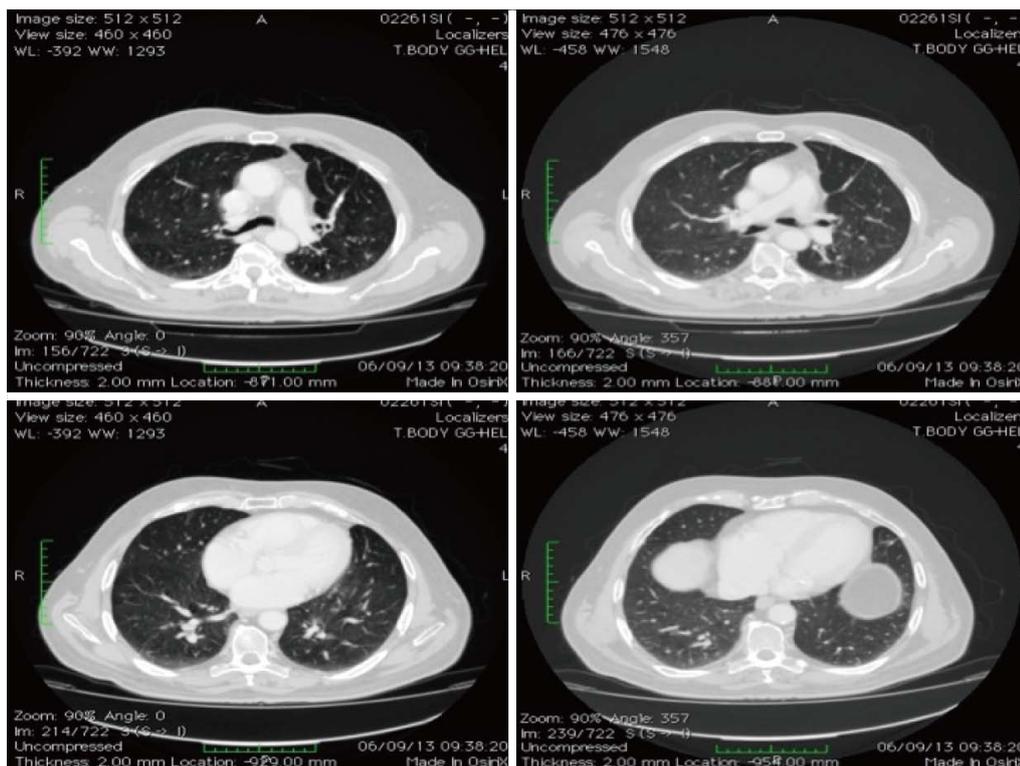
Thorax computed tomography-scan, showing the response at 60 mo since diagnosis (September 2013).
